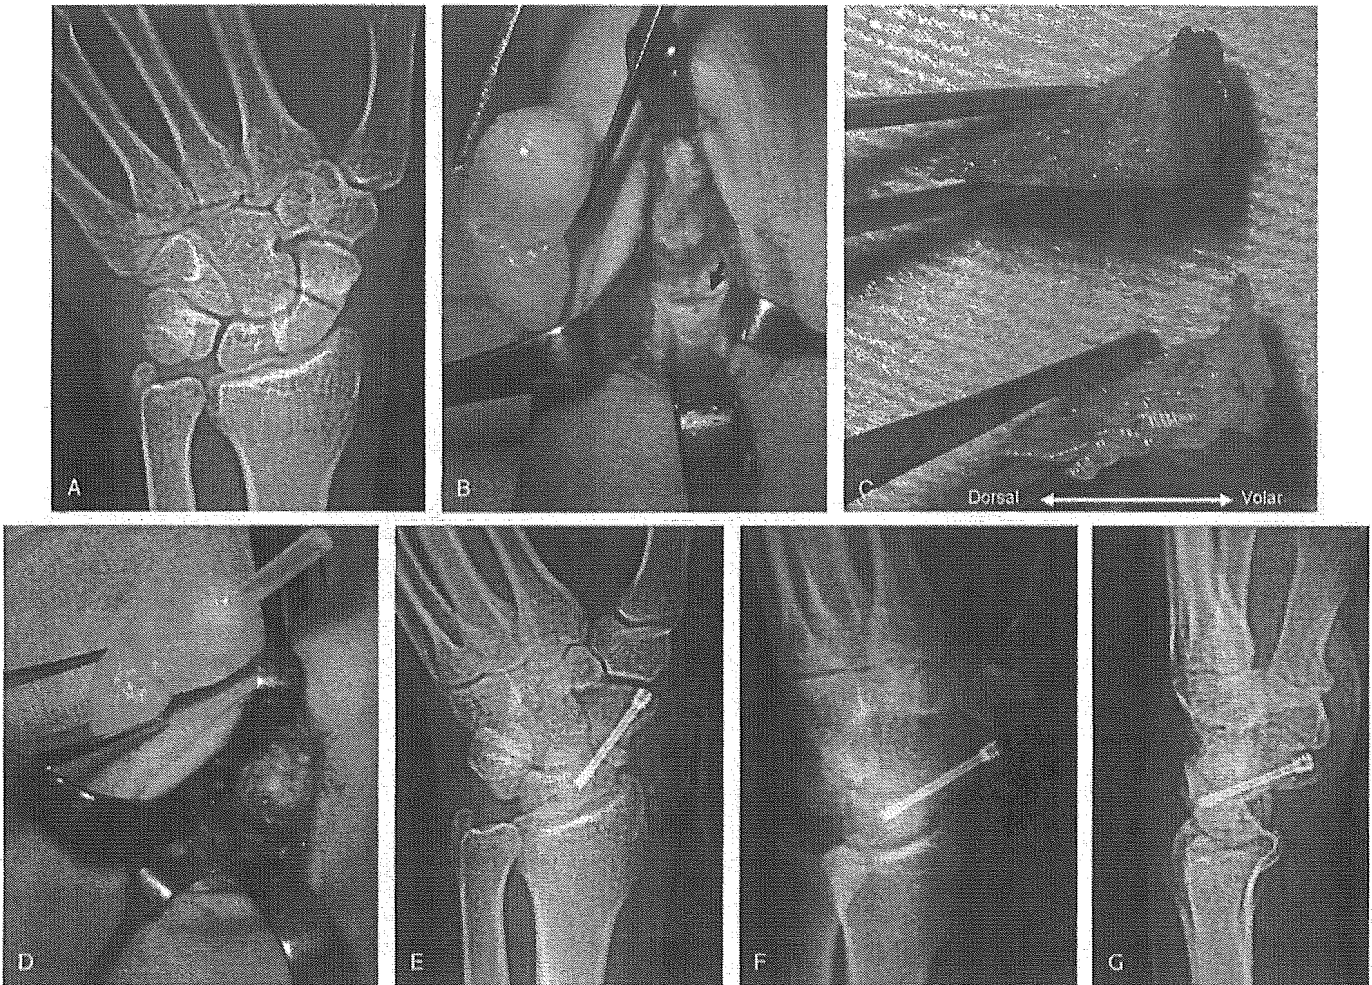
(A) A plain radiograph shows scaphoid nonunion at the waist in Patient 7. (B) A nonunion site (arrow) was compared with the hard model. (C) The iliac bone graft was shaped using the hard model as a reference. (D) After inserting the bone graft, the site and direction of screw insertion were determined using the hard model as a guide. (E) The radiograph immediately after surgery shows good reduction of the displaced fragments and proper screw placement. (F) Anteroposterior and (G) lateral radiographs obtained 6 months after surgery show solid bone fusion with normal alignment.
